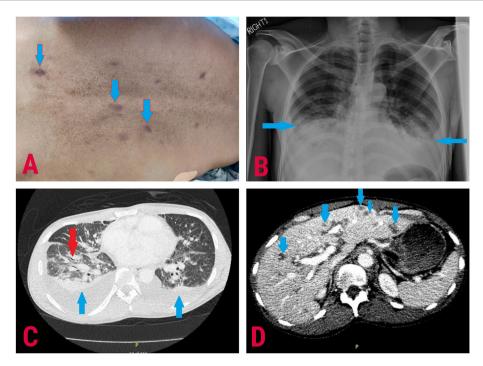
Disseminated Kaposi sarcoma. 1A. Cutaneous KS lesions on the back: There are numerous violaceous papulonodular skin lesions on the back (blue arrows). Skin biopsy showed plaque stage Kaposi sarcoma. 1B. Chest X-ray: bilateral pleural effusions (arrows) and infiltrates. 1C. Chest CT: Peribronchial thickening and diffuse thickening and nodularity of the bronchovascular bundles (red arrow) consistent with pulmonary Kaposi sarcoma. There were also bilateral pleural effusions (blue arrows). 1D. Abdominal CT with multiple liver nodules: There was hepatomegaly with numerous partial contrast enhancement hepatic lesions (blue arrows), consistent with hepatic Kaposi sarcoma.
